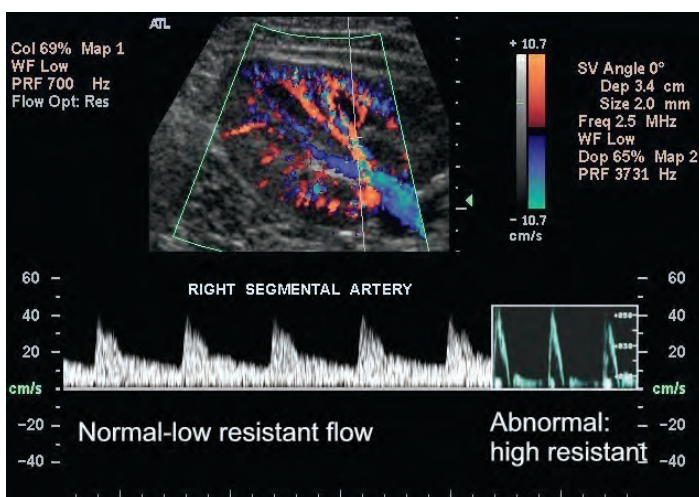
Transverse view of the right kidney, using a coronal approach. Doppler signals are obtained from a segmental artery within the kidney. Normally, the signals are low-resistance, as noted on the image with the first set of waveforms. In an abnormal (e.g., nephrosclerotic) kidney, the Doppler signal is high-resistance, as seen to the right.
